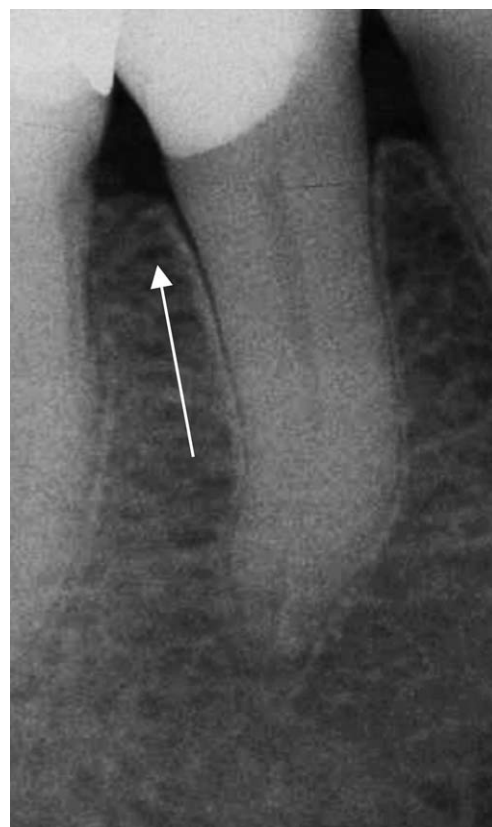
Radiograph of tooth #45 after 12 months. Radiographic examination revealed a distance of 1 mm between the restorative margin and the alveolar crest. Minimal loss of alveolar bone can be observed after 12 months (arrow).
